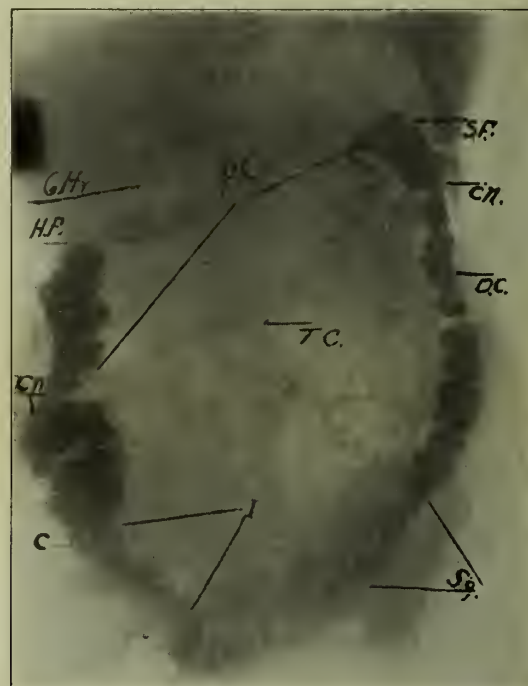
Same case as Fig. 13. I. Ileum. C. Cecum. H. F. Hepatic flexure. T. C. Transverse colon. P. C. Peristaltic contraction. S. F. Splenic flexure. Cn. Constriction. D. C. Descending colon. This radiograph was taken at the sixth hour after the administration of the meal. There was a mild diarrhea existing at the time of the examination, which caused the colonic contents to advance very rapidly. Peristalsis is initiated at the static angulation in the right transverse colon. It has progressed to the splenic flexure. While the portion of the bowel just in advance of peristaltic contraction is dilated under normal condition, so that this may appear to be a normal dilatation at the beginning of the descending colon, the fluoroscopic examination and other radiographs prove the existence of the constriction in the upper portion of the descending colon. This peristaltic wave will stop at this point. Then another one will carry it forward at a later period. The angulation in the right transverse colon is not demonstrated in Fig. 13 because it has been corrected by pressure.
